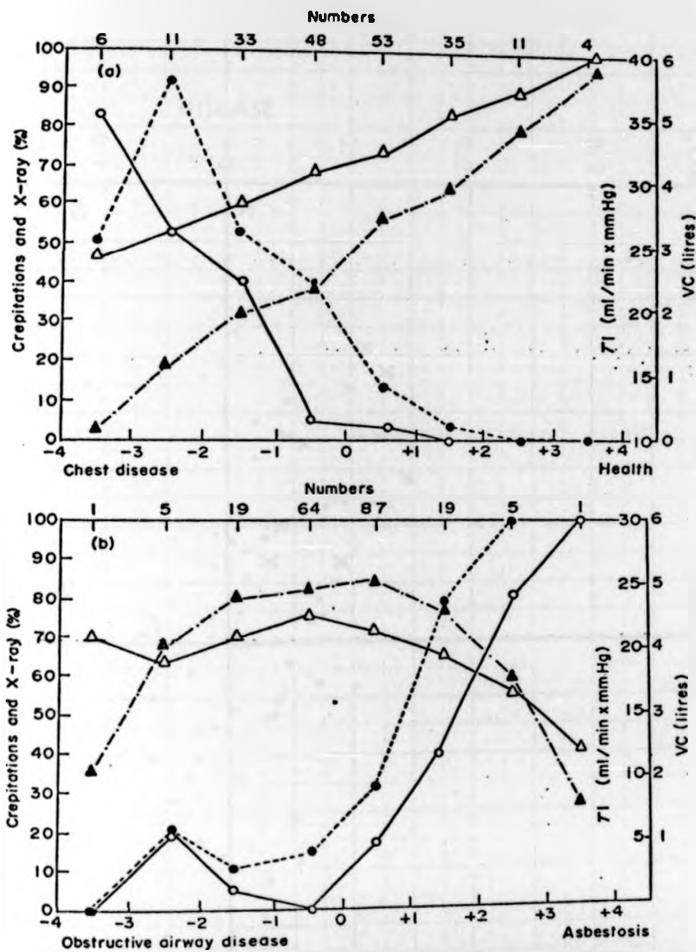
Unadjusted means of the transfer factor (TF) (Δ), vital capacity (VC) (Δ), and the prevalence of X-ray abnormality (\bullet) and crepitations (\circ) for subjects lying within (a) the horizontal intervals (component I) of the PCA (Fig. 1), and (b) the vertical intervals (component II) of the PCA (Fig. 1).
